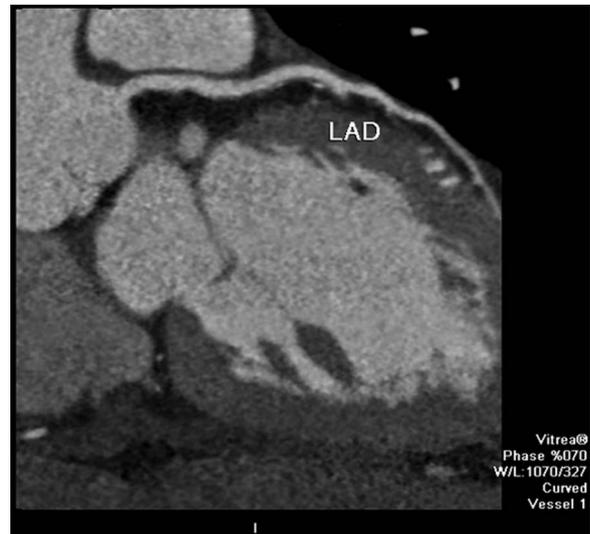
Multiple small plaques along the left anterior descending artery on CT coronary angiography.
